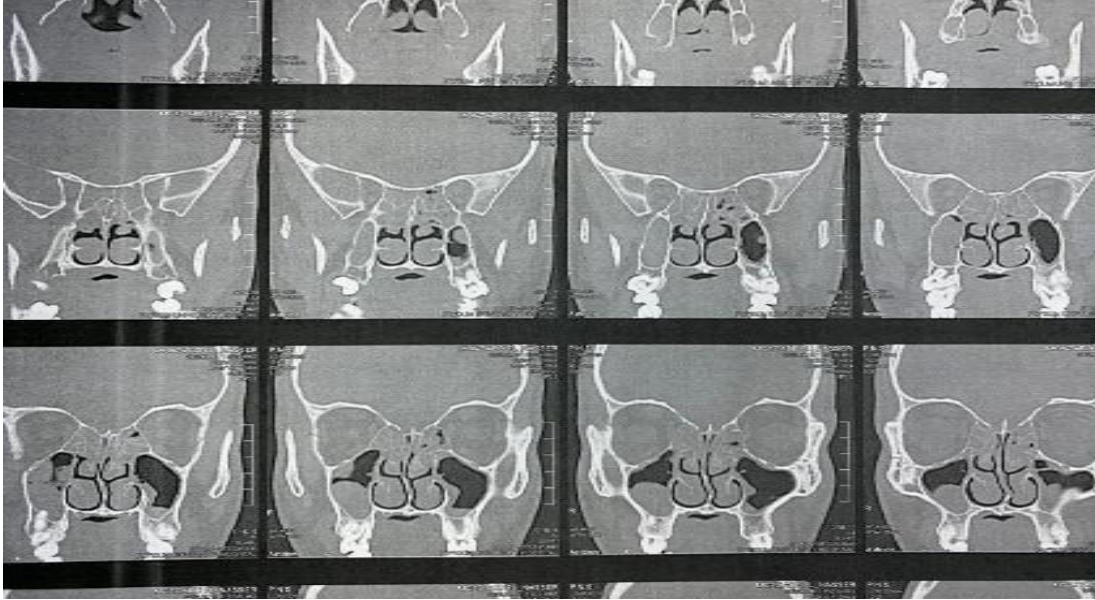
CT findings from different patients. A: partial opacification in the maxillary sinus and complete opacification of the anterior and posterior ethmoids.
